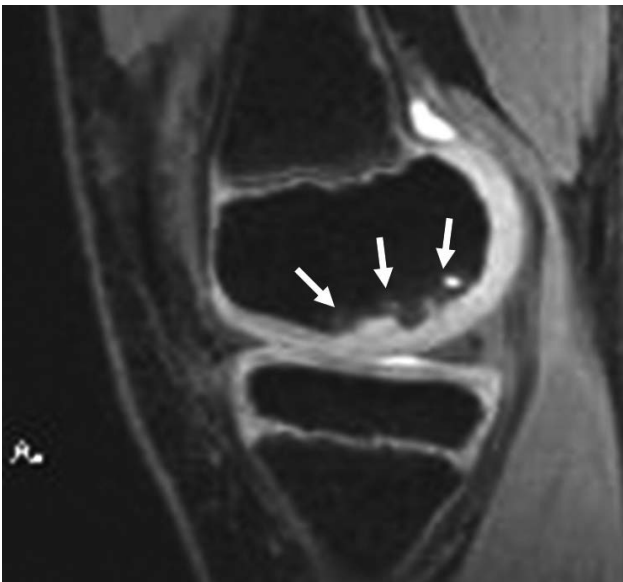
MRI – sagittal section showing OCD lesion (white arrows).
